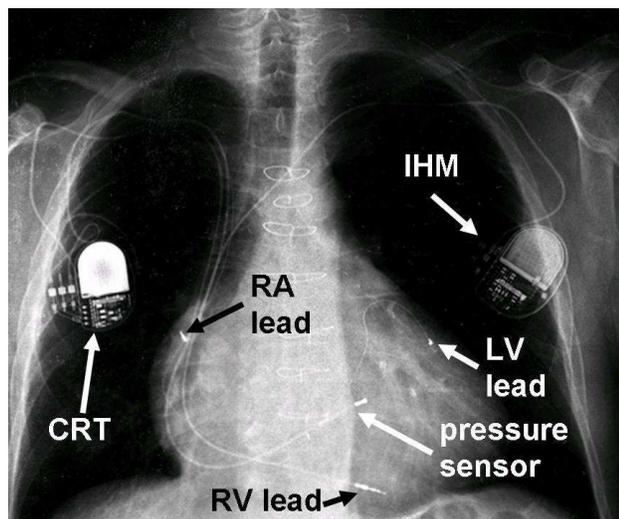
Chest x-ray of a study patient showing double implant of a cardiac resynchronization therapy (CRT) system including right atrial (RA), right ventricular (RV) and left ventricular (LV) lead in combination with an implantable hemodynamic monitor (IHM) system consisting of memory device and pressure sensor lead.
